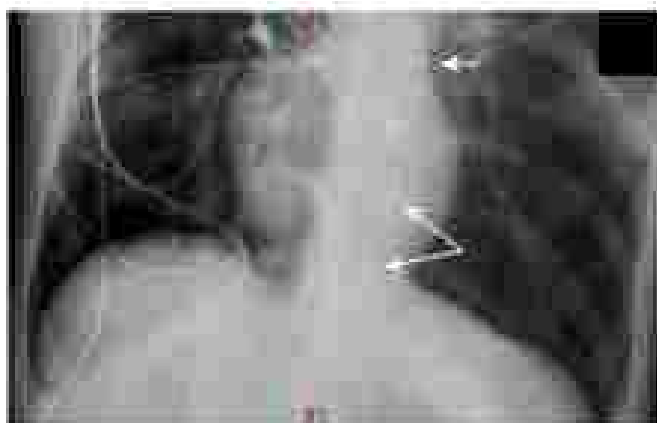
TR-BEBOA (Phyton Medical) can be seen in zone 1 for a patient with persistent hypotension, suggesting that a rapid posterior abdominal focused assessment with sonography for trauma exam. Chest radiography was used to confirm placement before inflation. Lung areas denote the proximal and distal extent of the balloon. Short arrow shows the end of the catheter.
